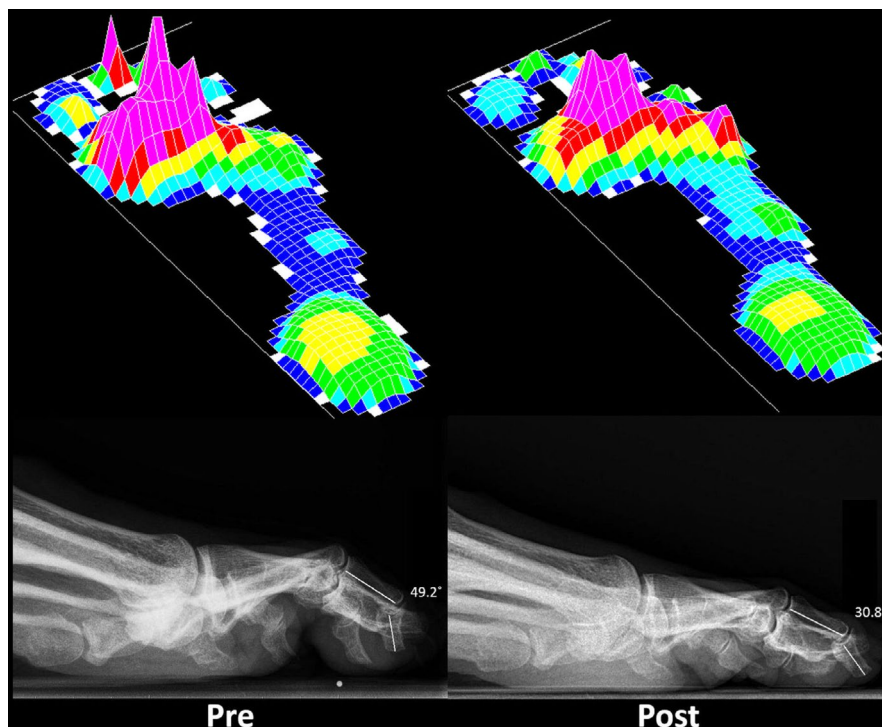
Barefoot plantar pressure from one step and radiograph of the right foot of a participant before and after flexor tenotomy on digitus 2, 3, 4 and 5. Barefoot plantar pressure underneath the apex of digitus 2 was 565 kPa before flexor tenotomy and 146 kPa after flexor tenotomy. DIPJ angle of digitus 2 was 49.2° before flexor tenotomy and 30.8° after flexor tenotomy
